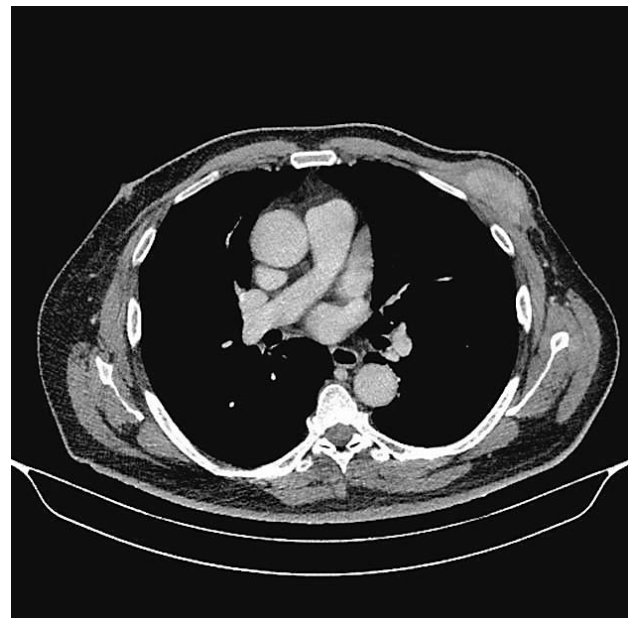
CT scan showing extensive relapse that infiltrates the large pectoral muscle and ribs, indicated by a blue arrow.
